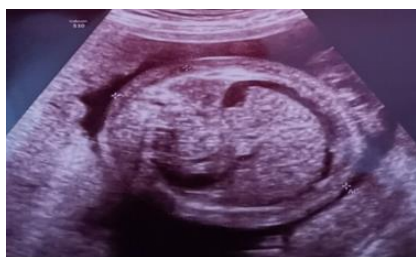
Obstetrical ultrasonography indicates fetal ascites and thick abdominal wall at 28 weeks POA
